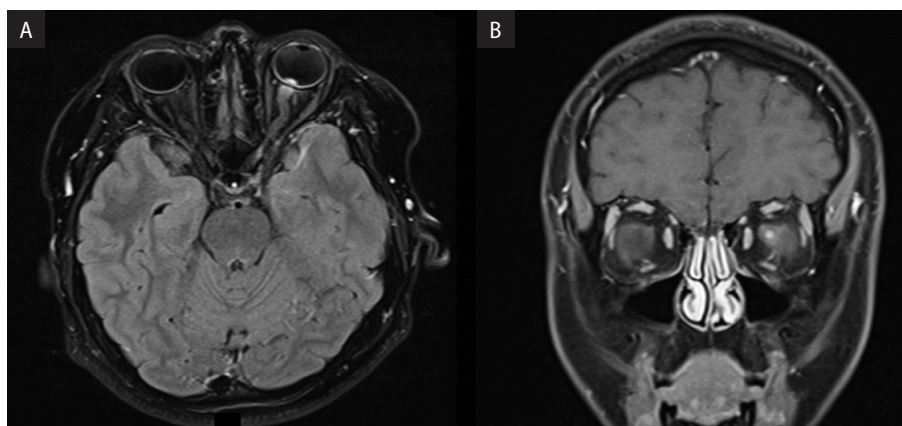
Magnetic resonance imaging (MRI) of head and orbits with T2 axial turbo T2 weighted spin echo (TSE) fluid attenuated inversion recovery (FLAIR) sequence (A) and T1 coronal TSE Dixon sequence with contrast (B). Focal enhancement of the anterior margin of the left optic nerve at its junction with the globe is demonstrated without other demyelination or parenchymal intracranial pathology
